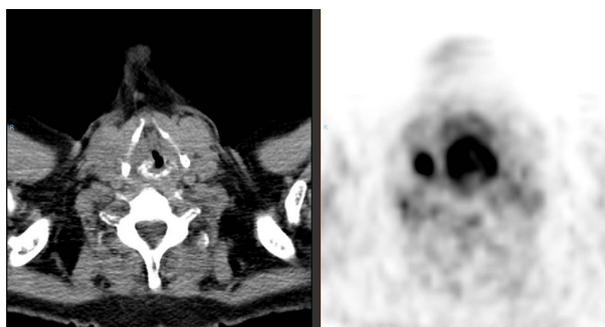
CT Scan and PET Scan of the Pathology
